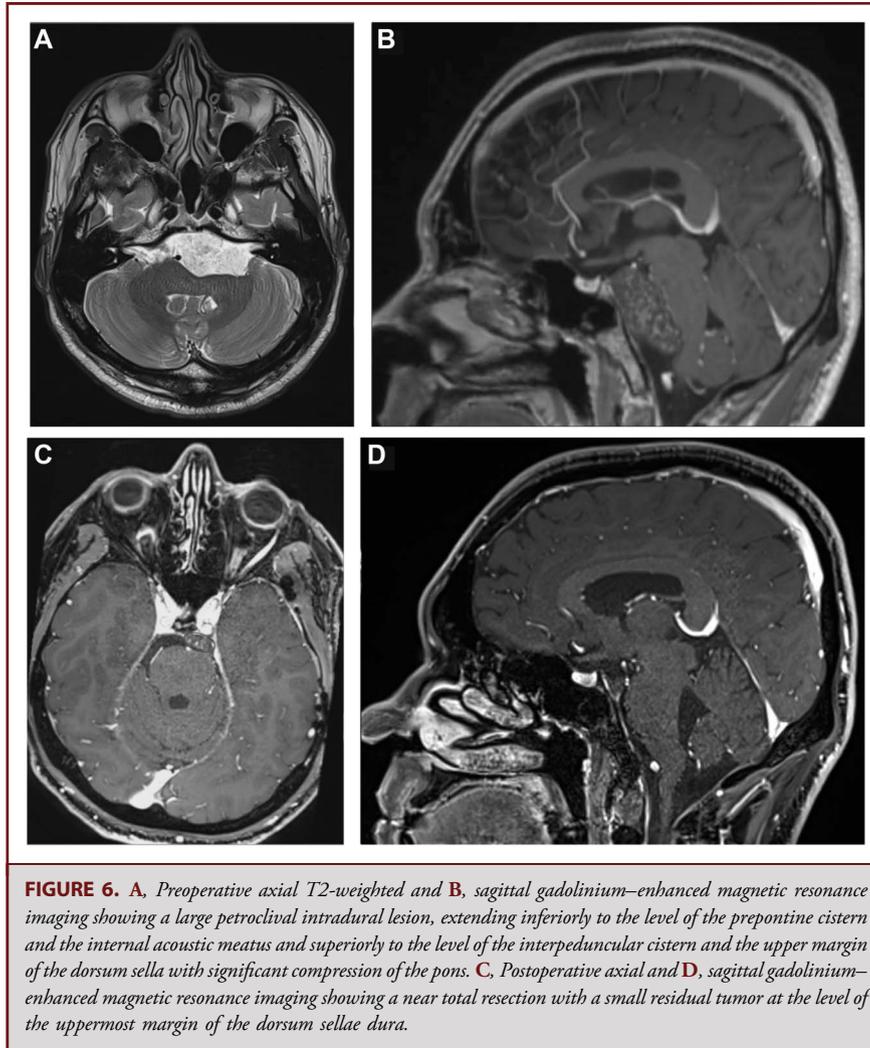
A, Preoperative axial T2-weighted and B, sagittal gadolinium-enhanced magnetic resonance imaging showing a large petroclival intradural lesion, extending inferiorly to the level of the preoptine cistern and the internal acoustic meatus and superiorly to the level of the interpeduncular cistern and the upper margin of the dorsum sellae with significant compression of the pons. C, Postoperative axial and D, sagittal gadolinium-enhanced magnetic resonance imaging showing a near total resection with a small residual tumor at the level of the uppermost margin of the dorsum sellae dura.
